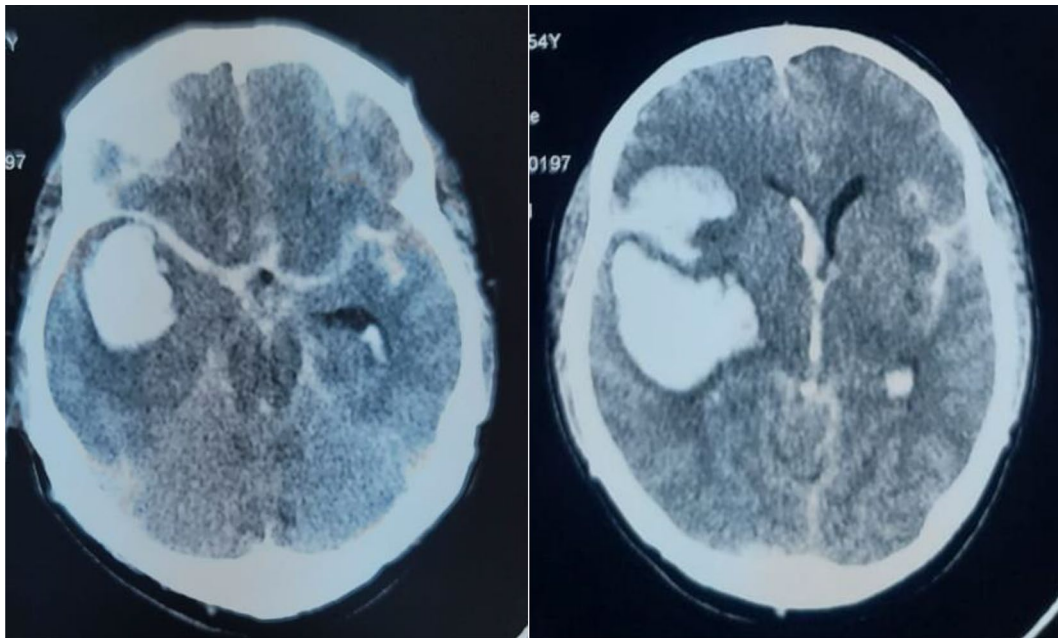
A computed tomography (CT) scan of the head revealed massive subarachnoid hemorrhage (grade IV according to the Fisher scale) with crowding of the basilar cisterns and a mass effect on the ventricles
